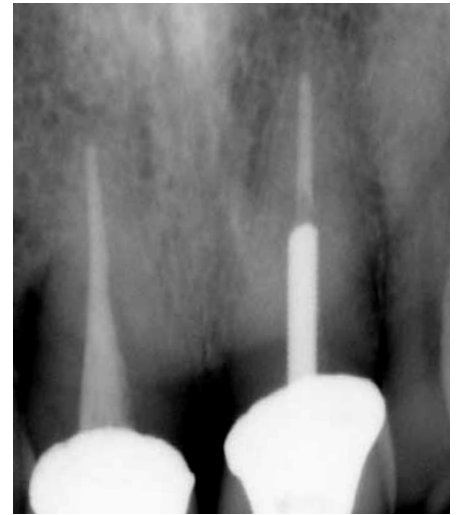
Starting radiograph.
